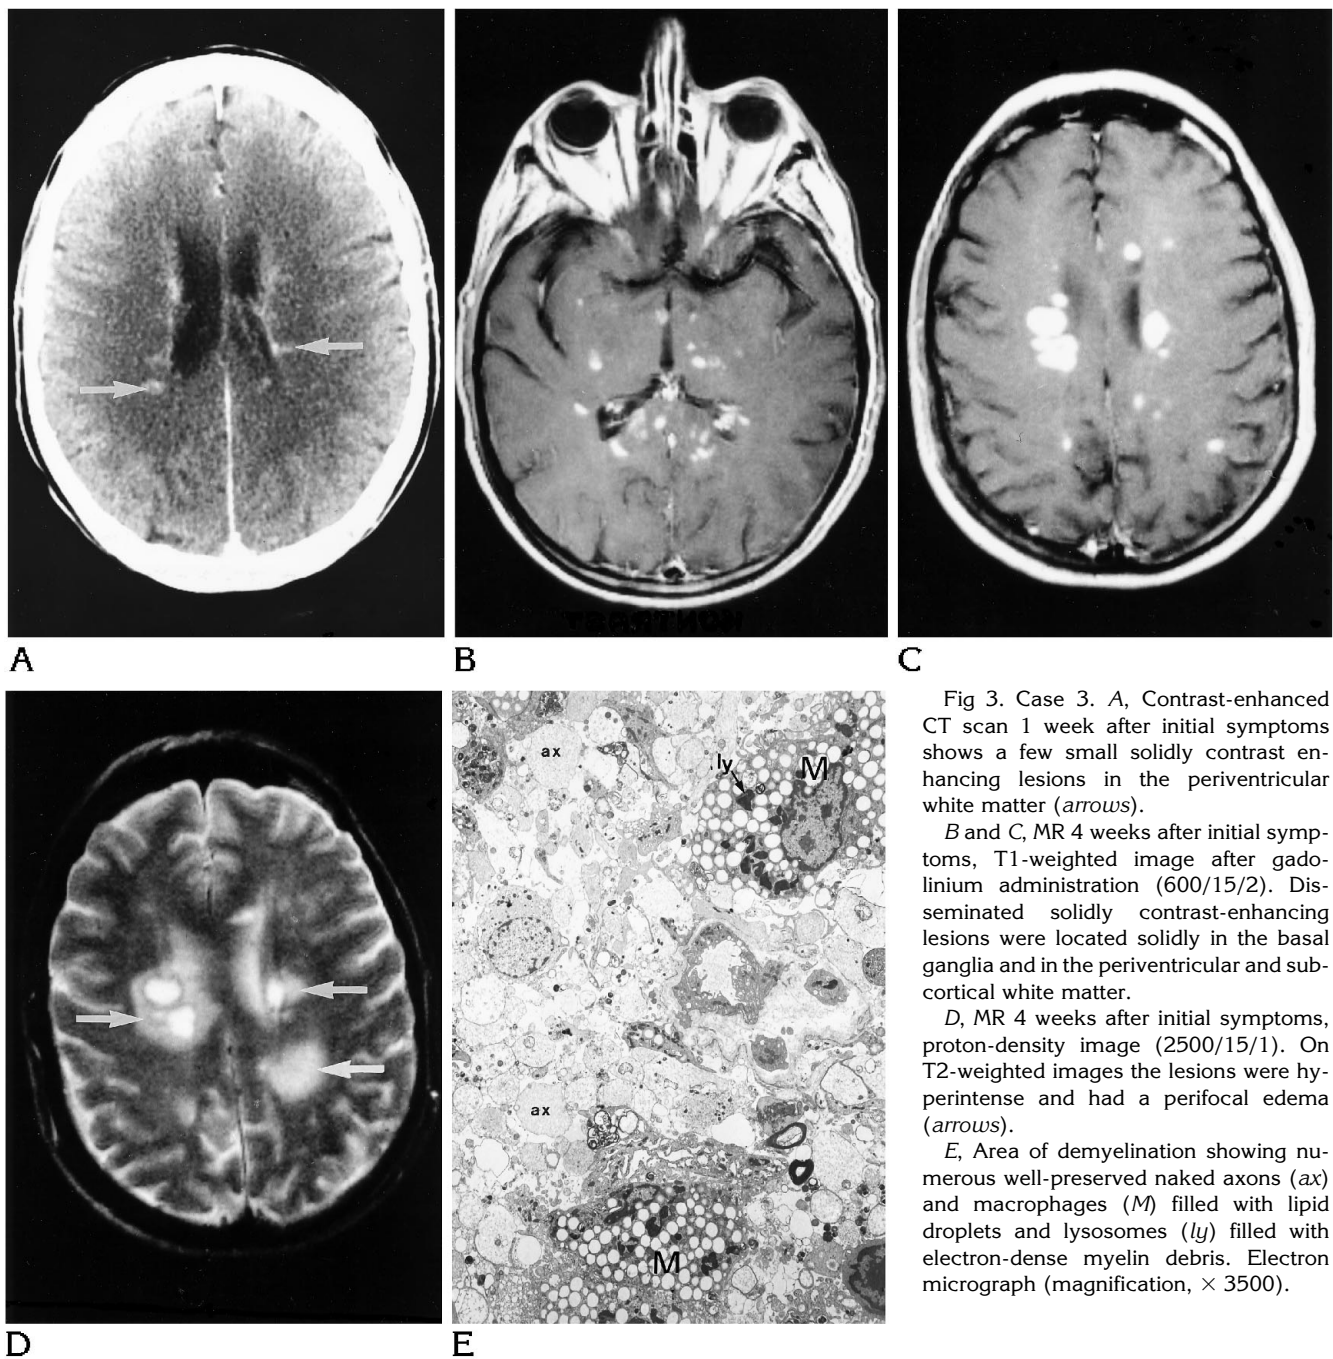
Case 3. A, Contrast-enhanced CT scan 1 week after initial symptoms shows a few small solidly contrast enhancing lesions in the periventricular white matter (arrows).
